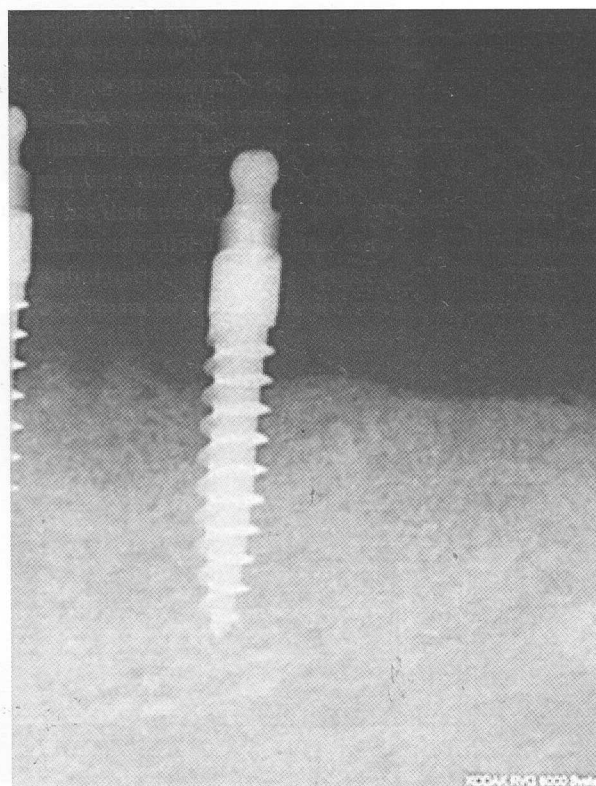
Periapical radiographs of lower left quadrant taken immediately after mini implant placement.
